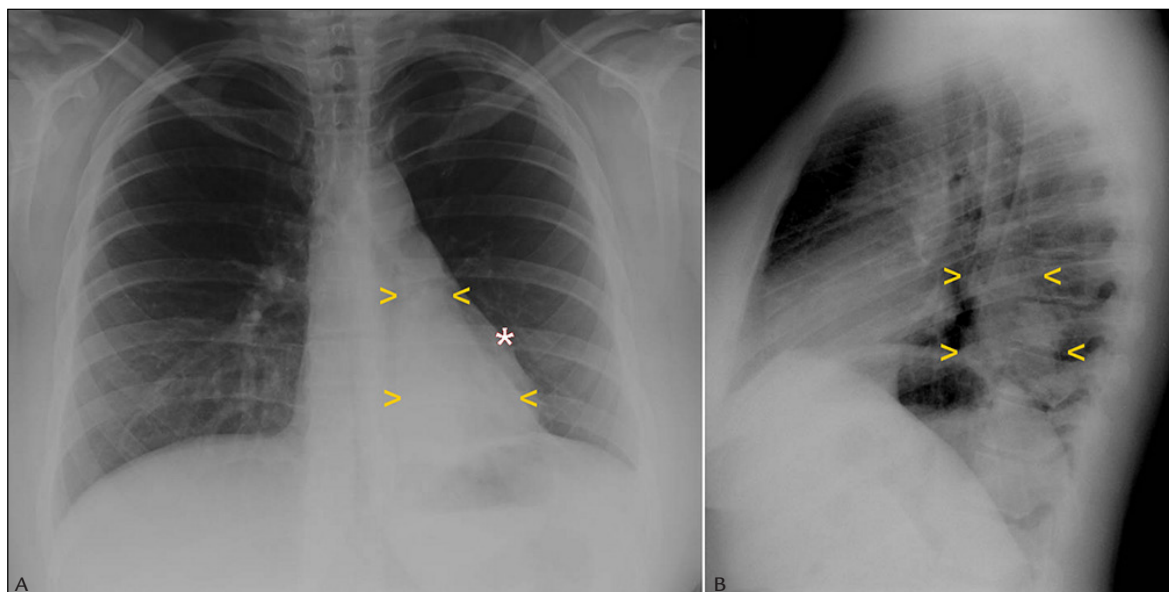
Chest radiographs in posteroanterior (A) and lateral (B) view revealing opacity at the left lung base (yellow arrowheads) within the retrocardiac space, appearing predominantly triangular with apex converging to the pulmonary hilum and base blurring of the edges of the diaphragm dome. Note the difference between the edges of the opacity in relation to the cardiac silhouette (*).
